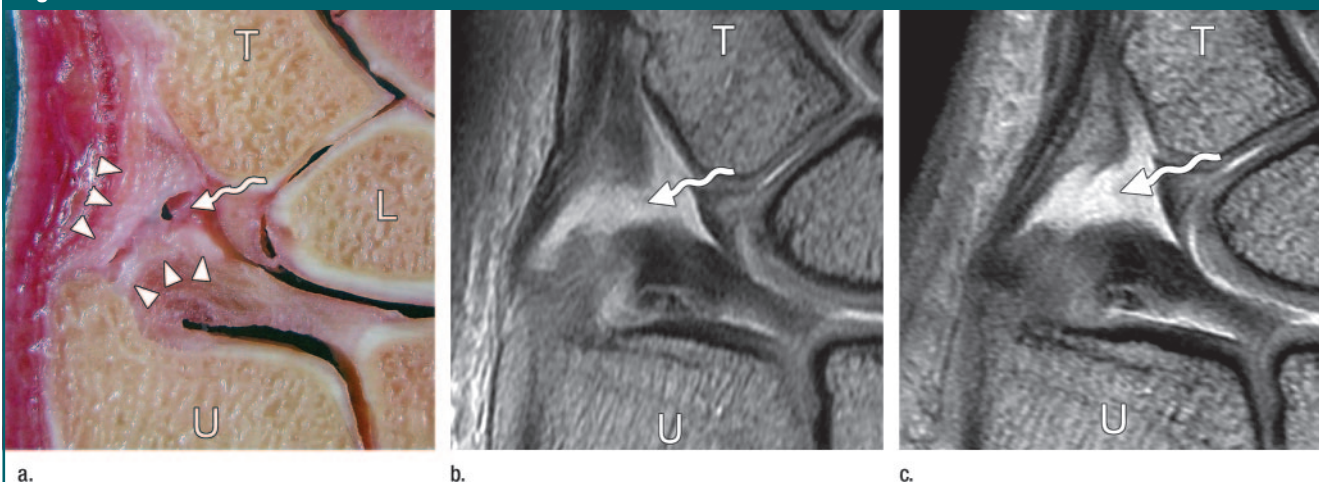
Narrow-opening UMH type with respect to the entrance to the prestyloid recess. (a) Anatomic section and (b, c) intermediate-weighted MR images obtained with the wrist in neutral position (b) and maximal radial deviation (c) are shown. *T* = triquetrum, *U* = ulna. (a) The styloid component of the UMH is recognized as white fibrous tissue (arrowheads). *L* = lunate bone. The entrance to the prestyloid recess (wavy arrow) is well seen. The entrance is clearly wider in c, mimicking the wide-opening type.
